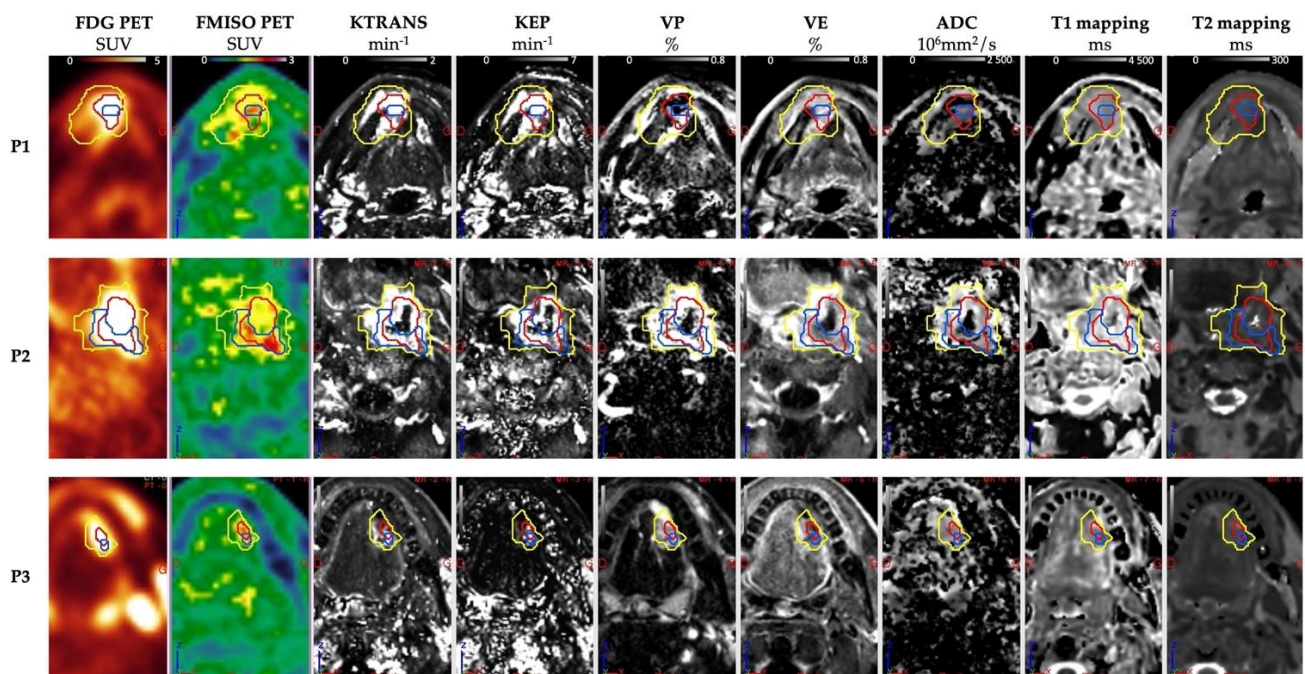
Multimodal PET/CT MRI images obtained from patients 1, 2, and 14 of the RETP8 population. For more details, see patient characteristics in Table 1. MRI tumor segmentation in yellow, FDG PET in red, and FMISO PET hypoxic subvolume in blue on each quantitative PET and MRI series.
